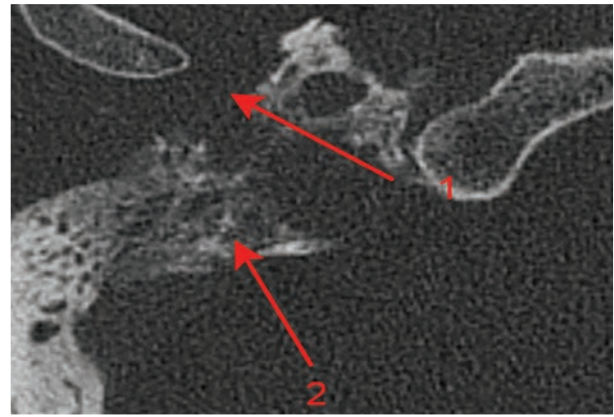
CT scan of the right temporal bone, axial projection. Type C paraganglioma: the posterior wall of the mandibular fossa is not observed in some places (1). The soft-tissue content that destroys the bone walls of the hypotympanum is observed at the level of the jugular fossa (2)
